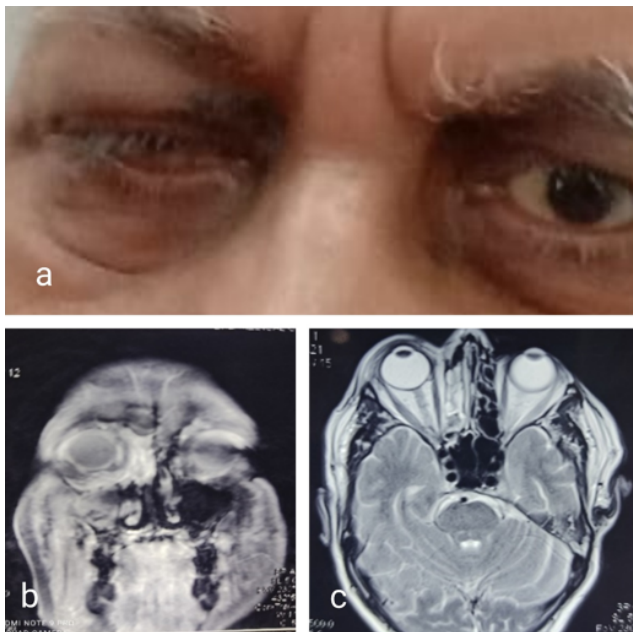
a: Post FESS; b,c: MRI showing soft tissue thickening in right ethmoid and maxillary sinus with stranding of right retro orbital fat with enhancing preseptal soft tissue.
